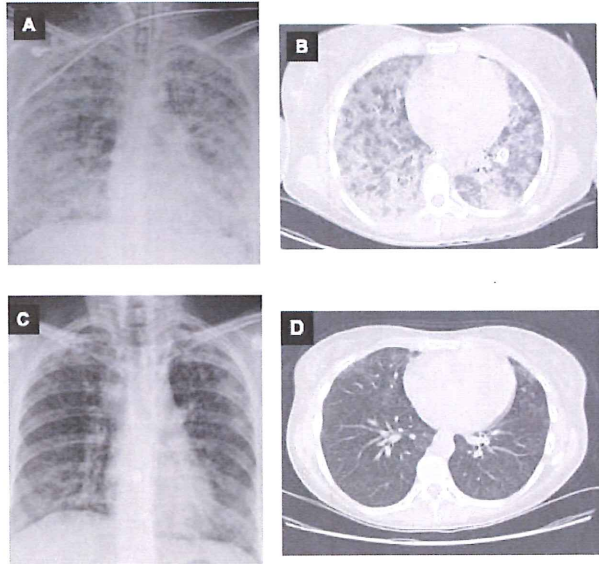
Chest radiographs and CT of patient 2 at transfer to the National Institutes of Health (day 10 of hospitalization; *A* and *B*, respectively) and 2 months after transfer (*C* and *D*, respectively). Note the remarkable resolution of infiltrates and the absence of pneumatoceles, despite the occurrence of pneumothoraces.
